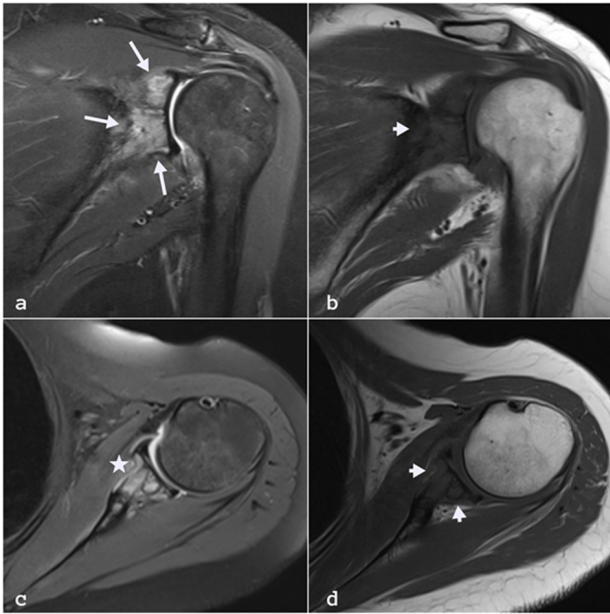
The left shoulder joint MRI examination; An expansile mass lesion is observed in the left scapula glenoid, covering the glenohumeral articular surface, heterogeneously hyperintense on coronal fat-suppressed PD-weighted sequence (a) and hypointense on coronal T1-weighted sequence (b). Fat-suppressed PD (c) and axial T1-weighted sequences (d) taken in the axial plane showed expansion in the anterior and posterior bone contour and destruction in the cortex, and joint extension was not detected.
